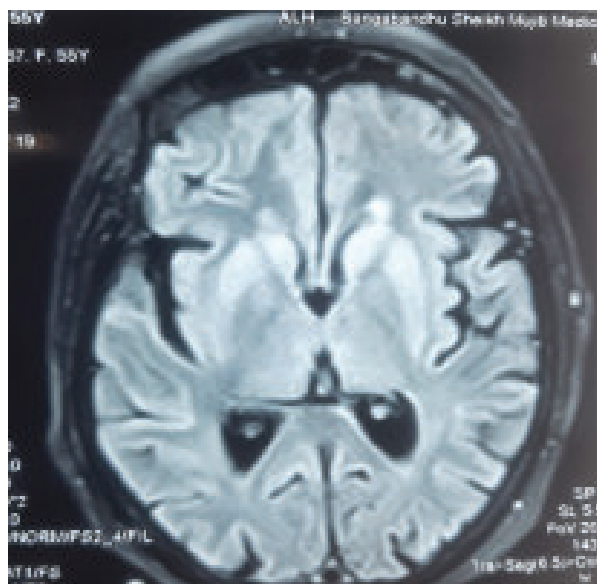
MRI of brain with FLAIR sequence showing hyperintensity of both basal ganglia (head of caudate nucleus and putamen).
